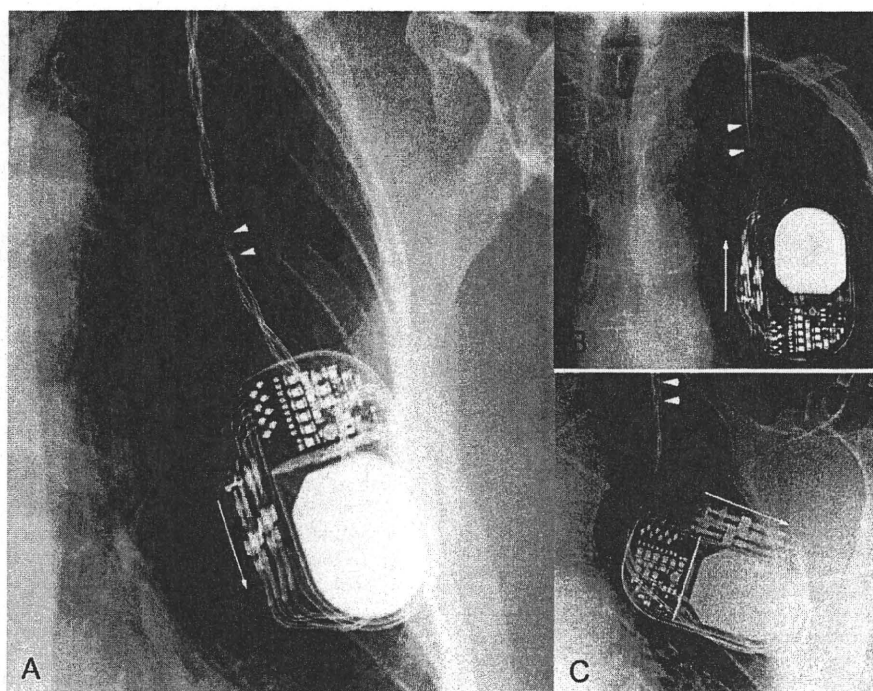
Radiograph of the left chest depicting a rotated neurostimulator (A) and non-rotated neurostimulators in the two most common positions of insertion: vertical (B) and horizontal (C). The connecting leads of the rotated neurostimulator are plaited around each other (Fig. 1A arrowheads) whereas the leads for non-rotated neurostimulators run parallel to each other as shown (Fig. 1B–C arrowheads). Additionally, the direction of the axis of the neurostimulator to connecting lead (long arrows) differs between rotated and non-rotated neurostimulators.
